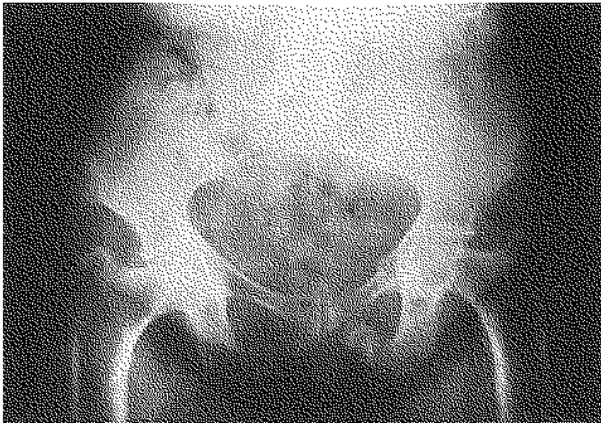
Standard xrays show a stress fracture of the left superior and inferior pubic ramus with surrounding callus formation.
